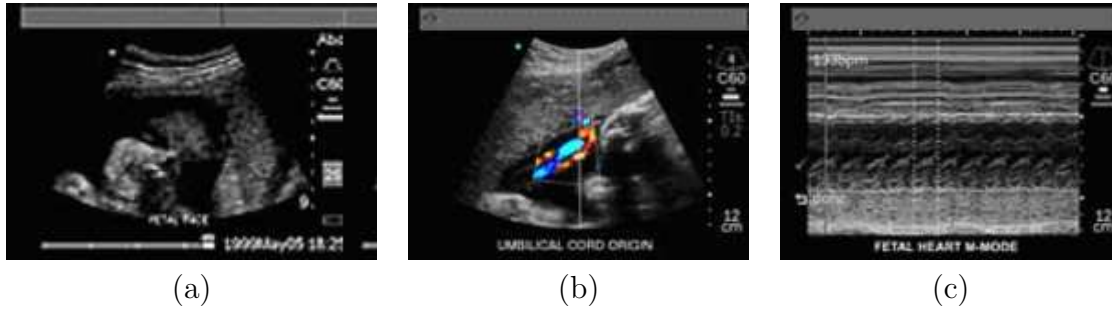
Ultrasound Imaging Modes: (a) B-mode, (b) Doppler imaging and (c) M-mode ultrasound.
